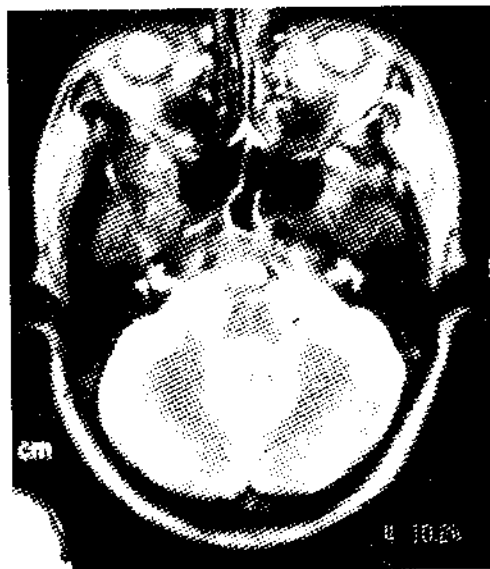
MRI scan of the same patient showing haemorrhage involving cerebellar vermis (A. T1 image, B. T2 image)
